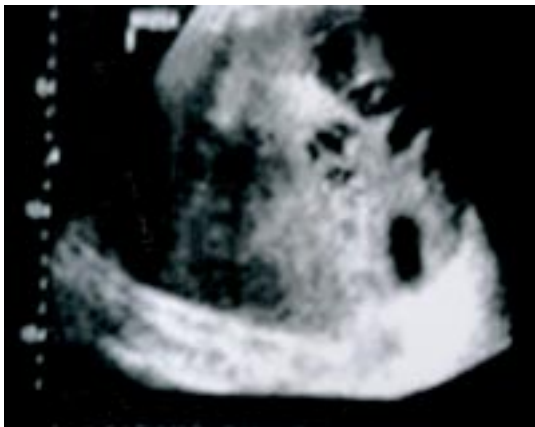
Ultrasound features of the large and complex left adnexal tumour.
